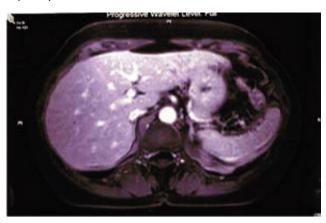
Magnetic resonance imaging of the liver done 9 months after initial presentation was essentially normal.
